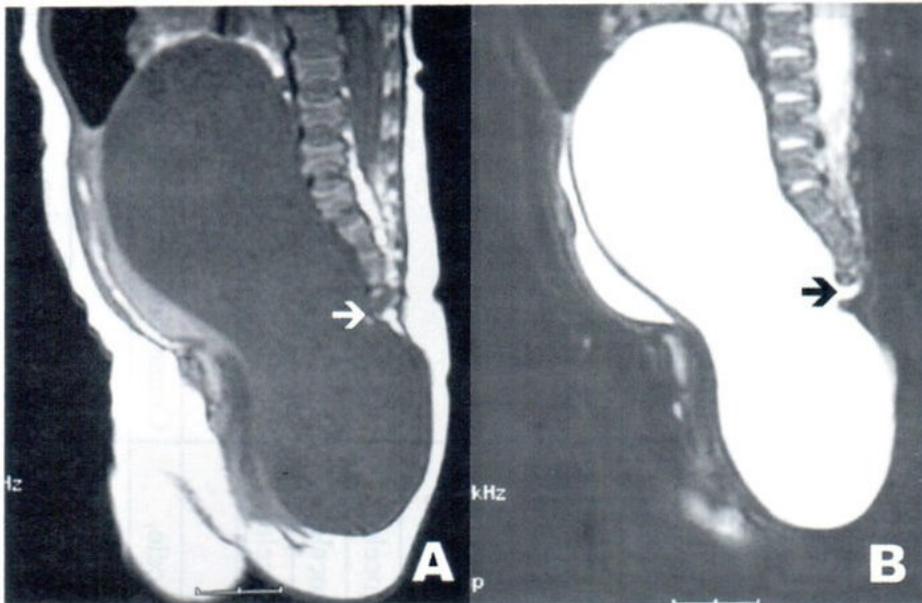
Anterior sacral meningocele. Sagittal T1-weighted image (A) and sagittal FSET2-weighted image with fat suppression (B) show a large cyst in the pelvic cavity and lower abdomen. Note a small connection between the cyst and the spinal canal (arrows) and pressure erosion of the anterior aspect of the sacrum.
